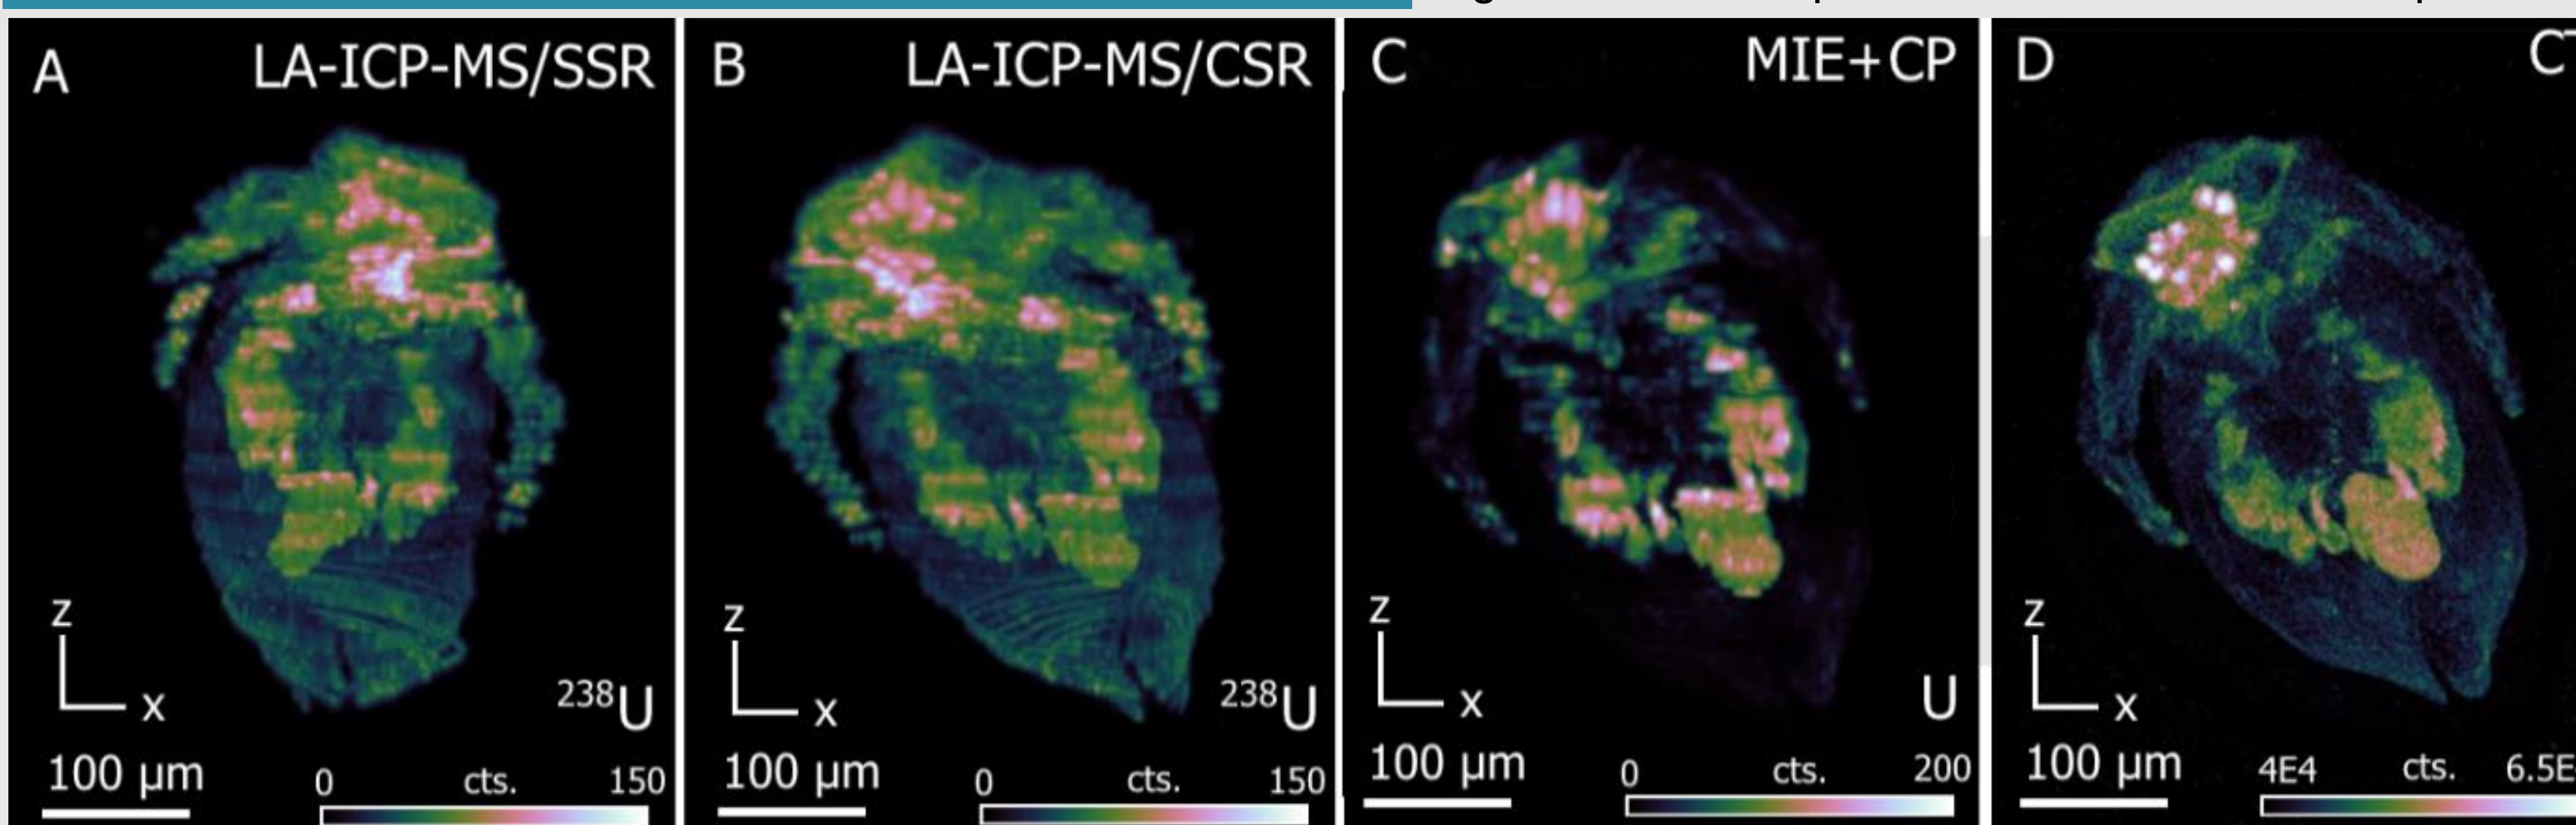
Frontal view of the results: (A) ^{238}U SSR reconstruction (B) ^{238}U CSR reconstruction (C) Elemental information (Uranium) through LA-ICP-MS/ μ -CT data fusion (D) μ -CT image (signal intensity is a proxy for electron density)
